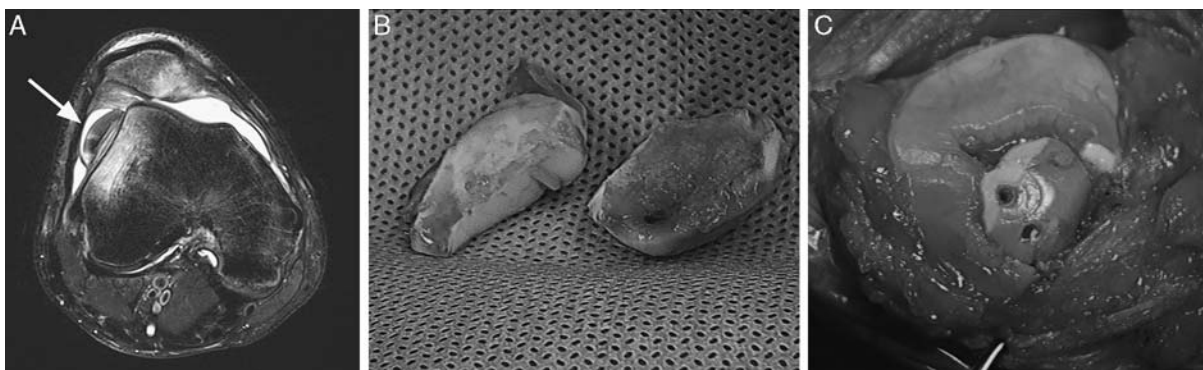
Magnetic resonance imaging after an acute high-energy patellar dislocation. The arrow indicates a large osteochondral body from the medial facet of the patella (A). This fragment was excised and 1 portion (right side) was found to have bone attached, while 1 section (left side) did not (B). This fragment was affixed to the medial side of the patella with biocompression screws (C).
